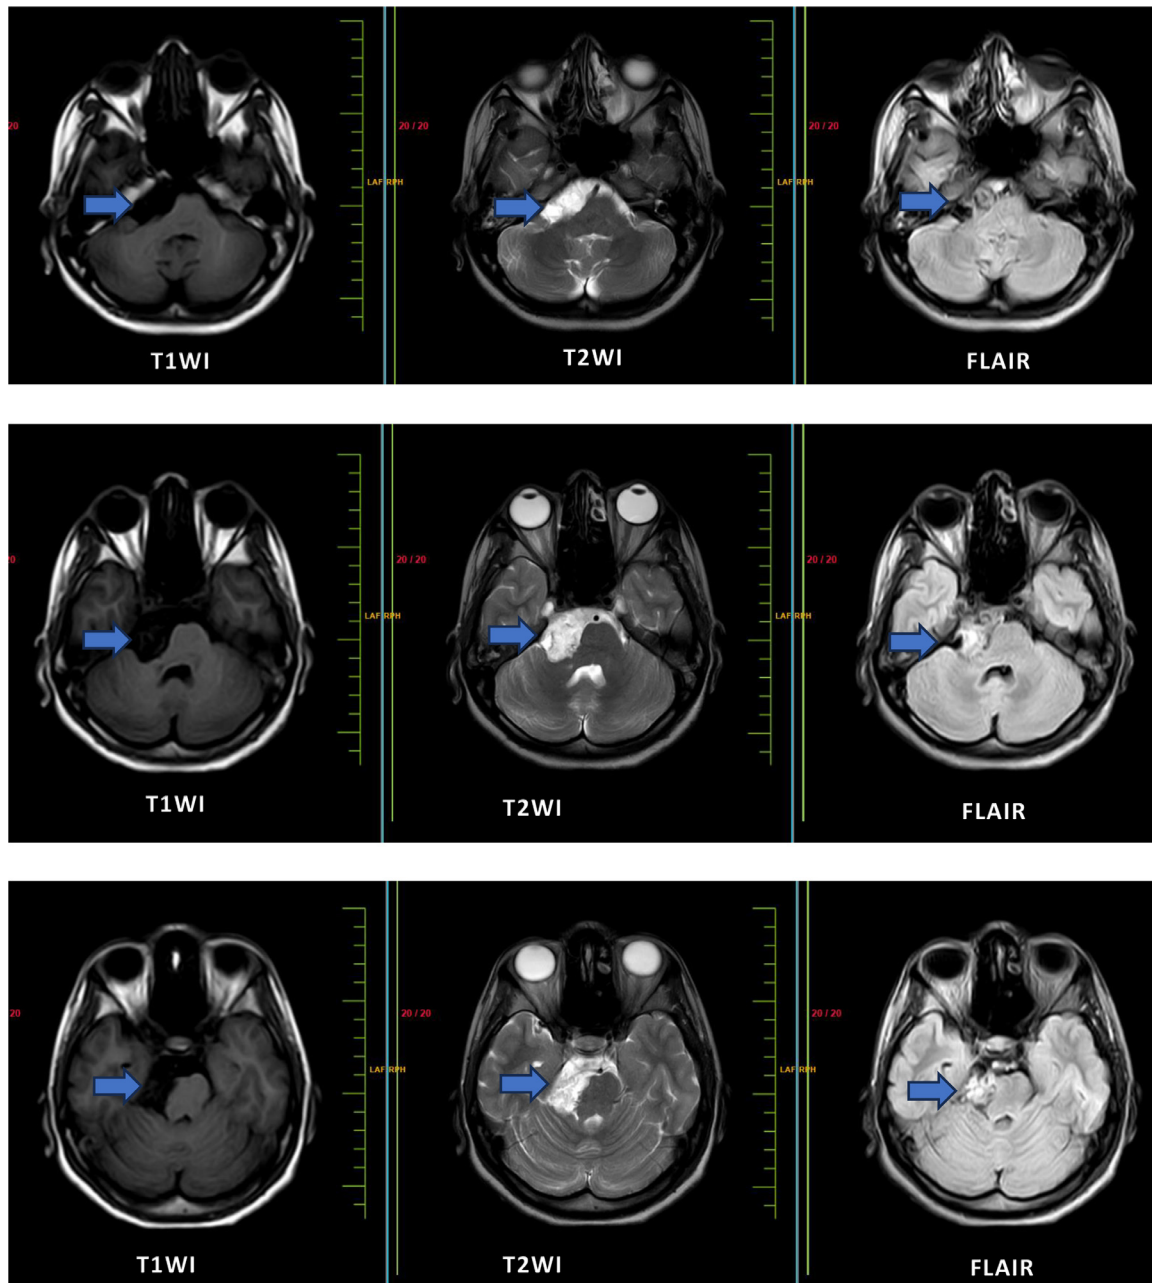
(A-C) – MRI Brain Axial sections showing cystic lesion in right cerebellopontine (CP) angle cistern appearing hypointense on T1WI, hyperintense on T2WI, showing dirty hyperintensity on FLAIR.
